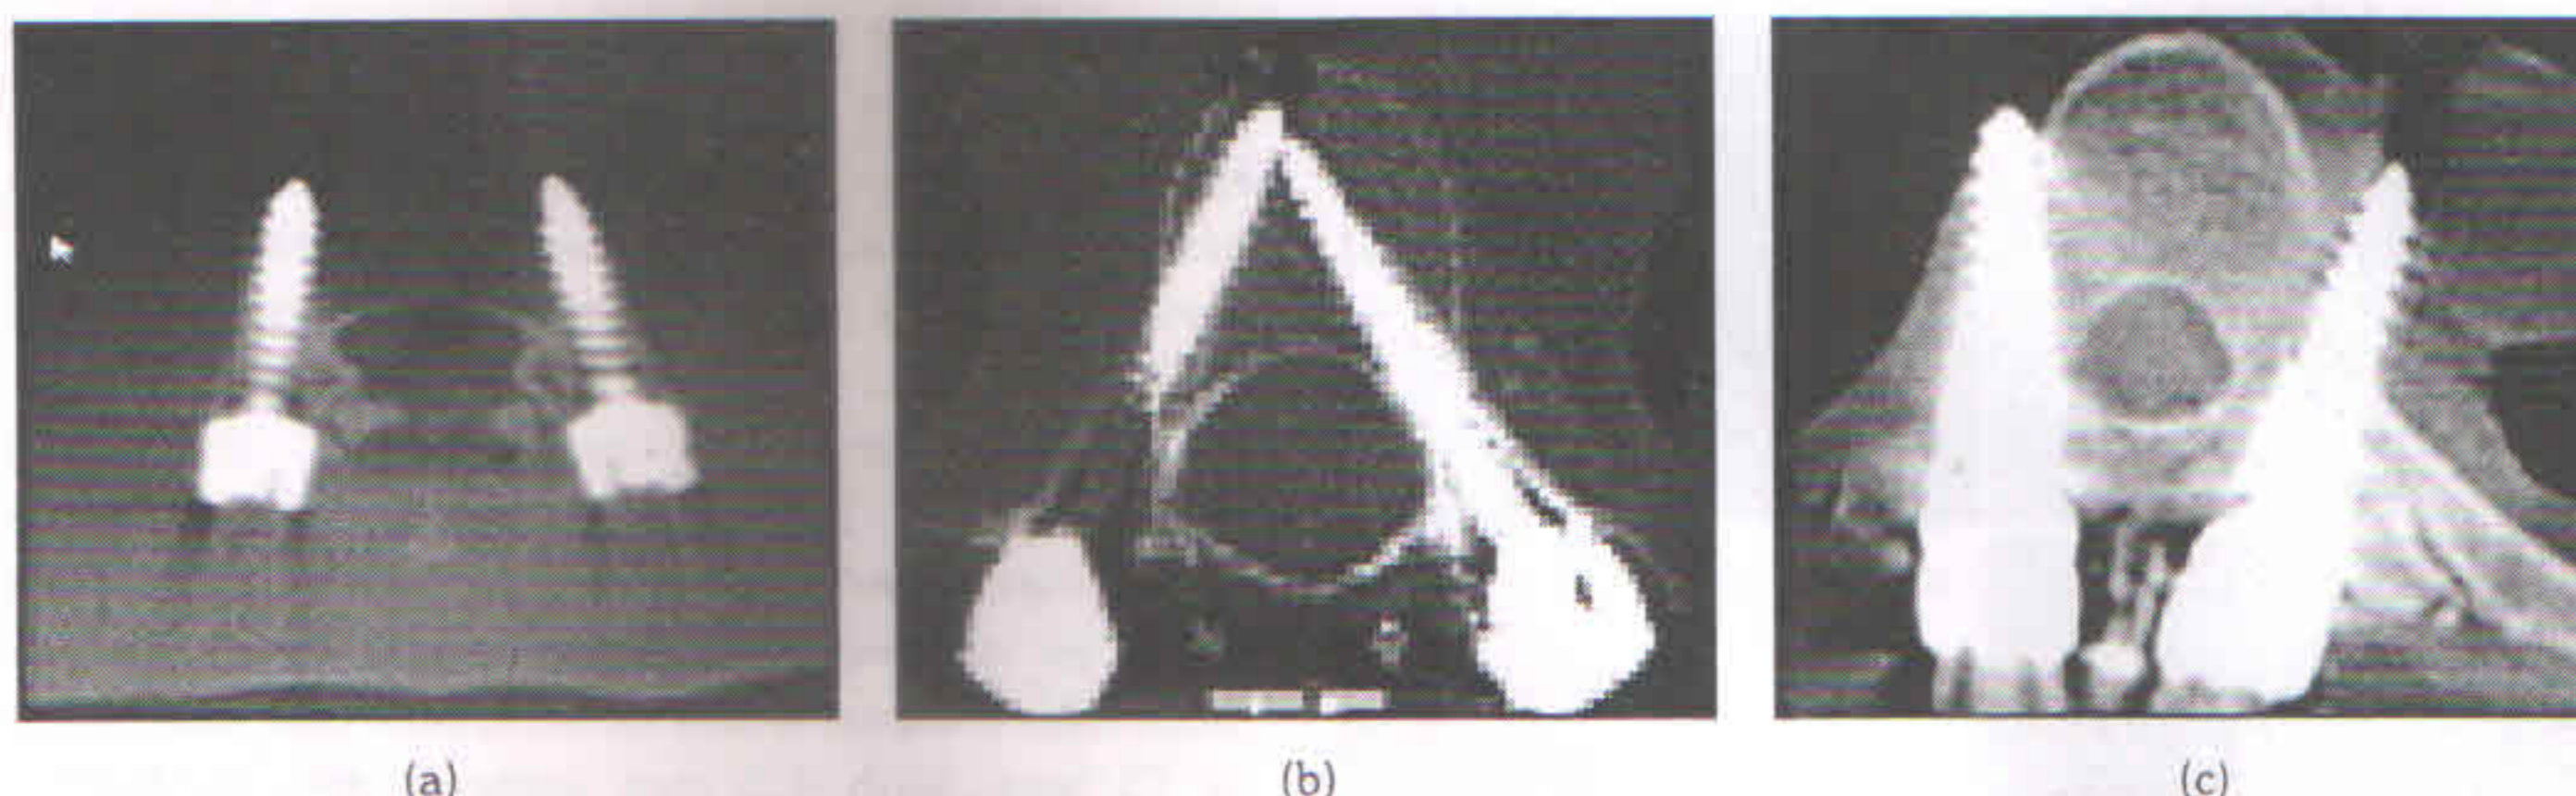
Post operative CT Scan showing (a) no breach (b) medial breach (c) lateral breach of screw tip
